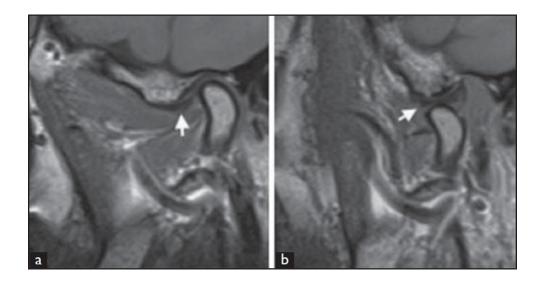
T1-Weighted sagittal MRI (a) closed- and (b) open-mouth positions showing anterior disc displacement with reduction (arrows).
